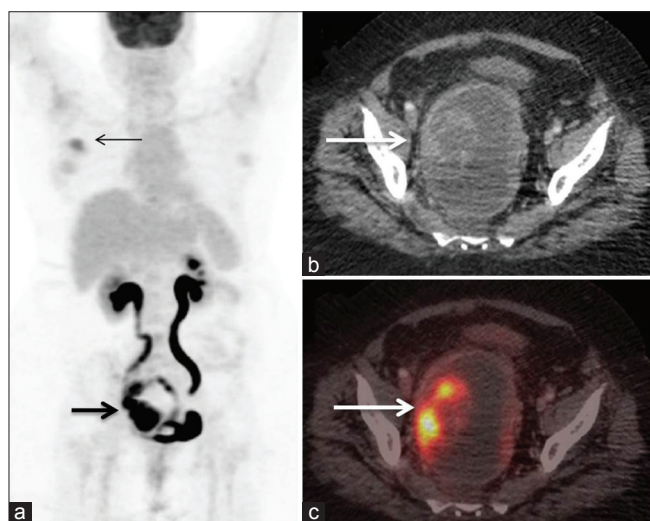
(a) Whole-body, maximum-intensity projection image showing focal increased uptake in the 2.5-cm lesion in the upper quadrant of the right breast (thin black arrow) and abnormal fluorodeoxyglucose-avid lesion in the right side of the pelvis (bold black arrow). (b and c) Transaxial contrast-enhanced computed tomography and fused positron emission tomography/computed tomography images showing incidentally detected large metabolically active solid cystic mass in the right adnexa (bold white arrows) confirmed as malignant posttotal abdominal hysterectomy and bilateral salpingo-oophorectomy
